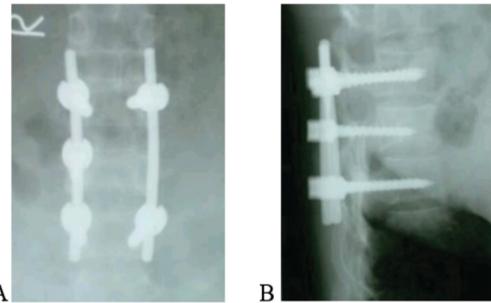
One Year Follow Up X-ray Ap View(a) and Lateral View (b) Showing Fracture Union and Maintenance Of Deformity Correction.
